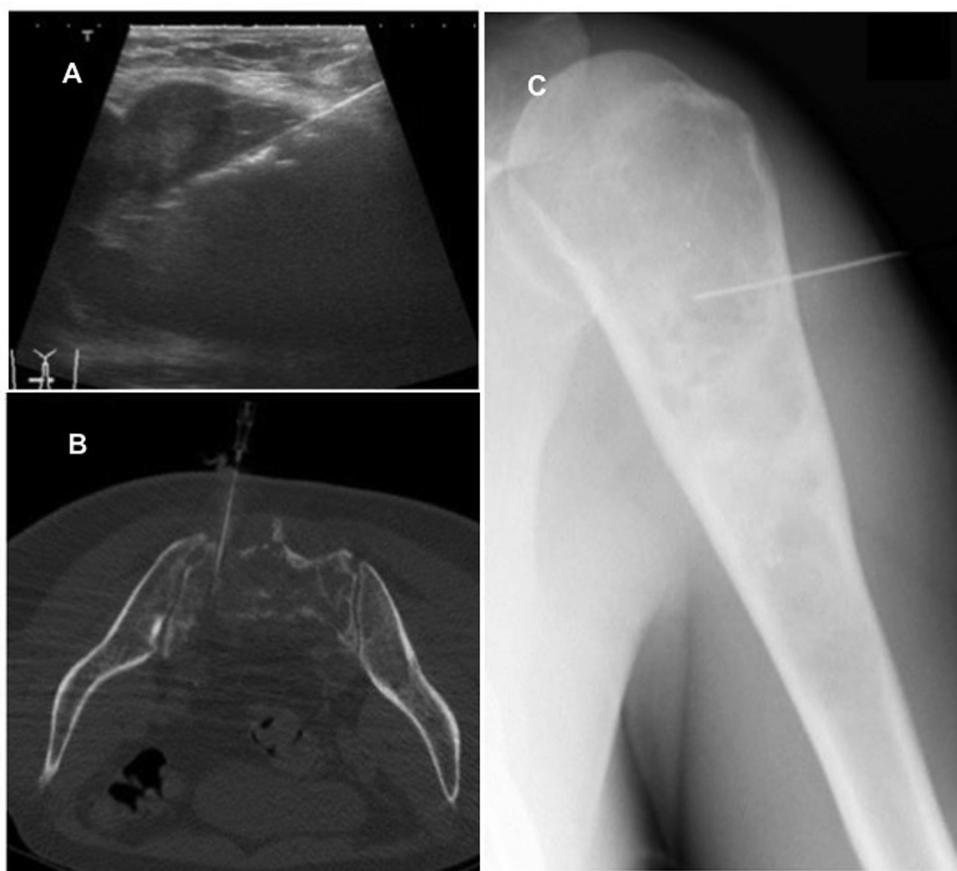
Examples of the imagiological methods used for tumour localisation: A) Ultrasonographic view of a soft tissue lesion in the thigh, B) Identification of a bone lesion in the sacrum using CT, C) Identification of a bone lesion in the humerus using X-ray.
